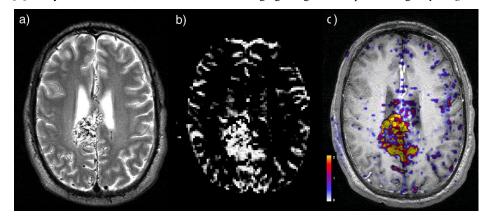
Patient with AVM: a) T2-weighted image, b) SE-DCE-MRI, c) quantified perfusion in ml/(s*ml) overlayed to T1-weighted image.
